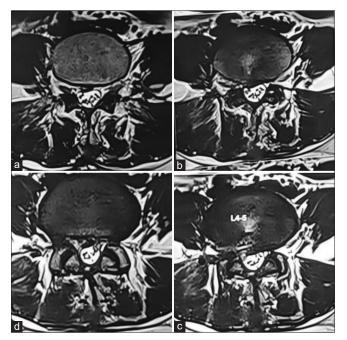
Postoperative T2-weighted axial Magnetic resonance imaging demonstrating the decompression at (a) L4 lower-end plate, (b) upper discal margin, (c) mid-discal level, and (d) lower discal margin.
